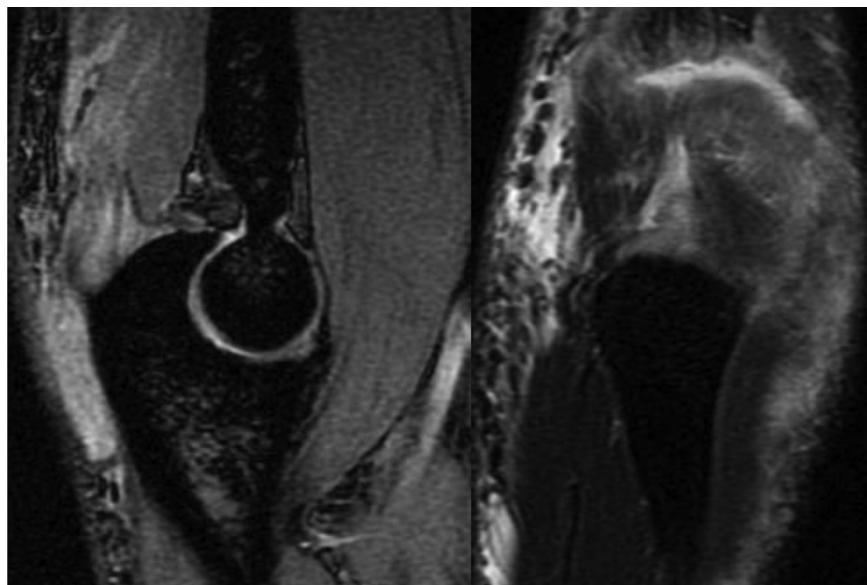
Magnetic resonance imaging (sagittal and coronal) showing partial tearing of the tendon of the distal triceps.
